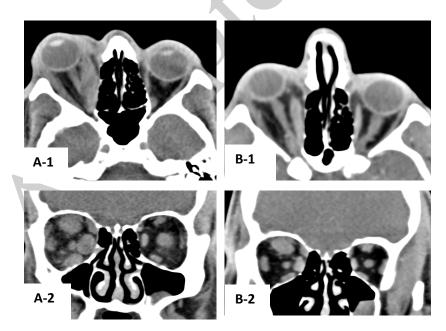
CT scan of orbits showing good response to treatment, pretreatment (A1- A2), post-treatment (B1- B2).
